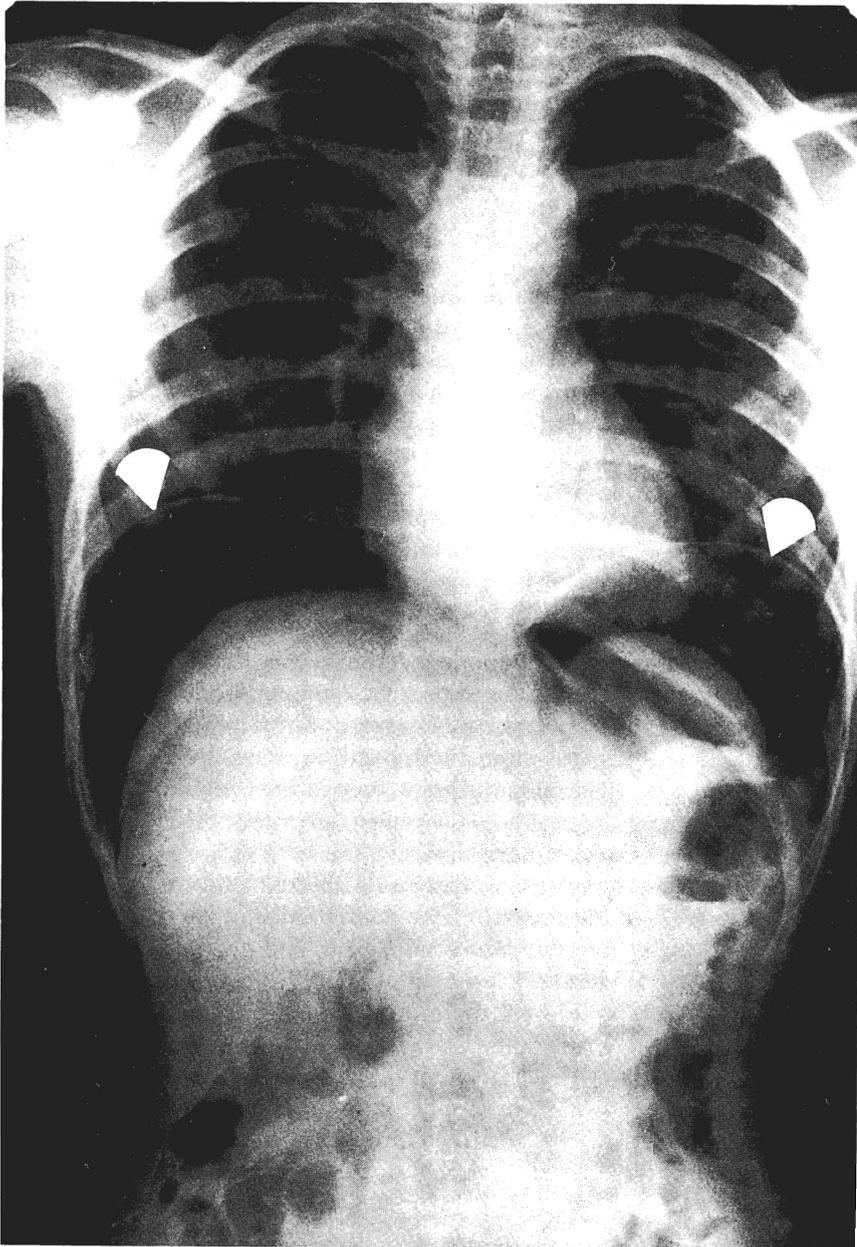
Free air. Free intraperitoneal gas on upright radiograph of child with traumatic bowel perforation. (Courtesy of Dr. William Holland)
